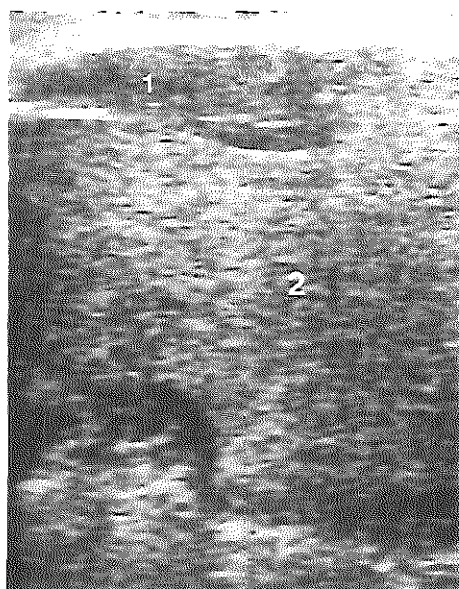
Transverse ultrasound section of the floor of the mouth in the same patient. The digastric muscle (1) is demonstrated superficial to the dermoid cyst (2).
